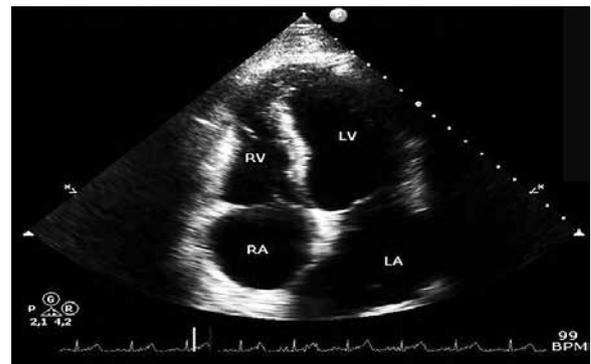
Image of postoperative transthoracic echocardiogram in an apical view with visualization of the four heart chambers demonstrating thickened pericardium, however, without the cystic formation. Source: personal archive.
